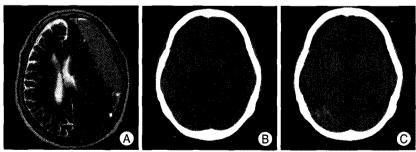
A: Late, subacute phase, chronic subdural hemorrhage in the left frontoparietal area on T2-weighed MRI. B: CT on the second postoperative day demonstrating decreased subdural fluid collection and the presence of pneumocephalus, but no abnormal signal in the cerebellum C: Hemorrhage in the right cerebellum on the fifth postoperative day.
